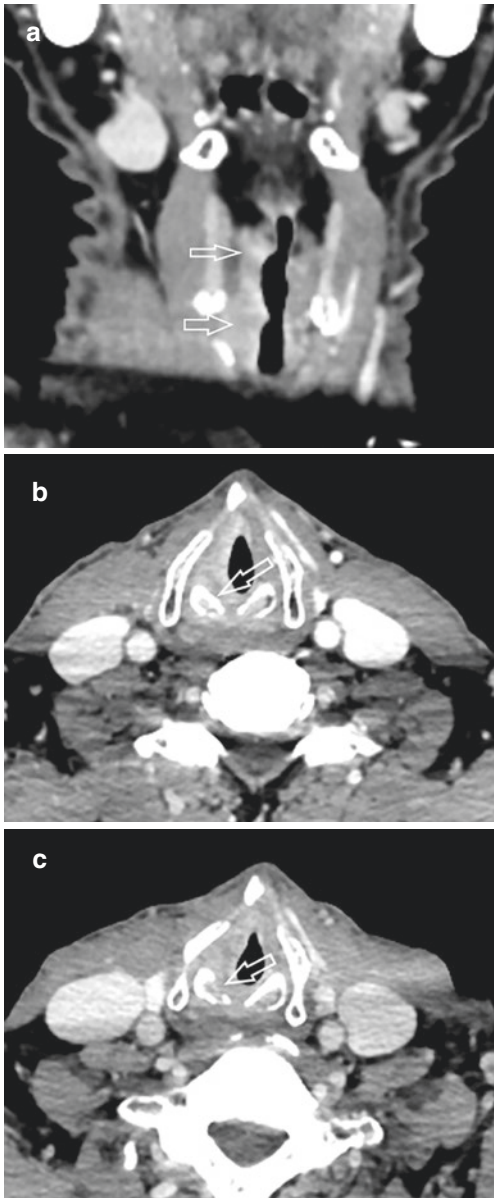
Laryngeal cancer. This patient presented with hoarseness for 3 months. (a) Coronal contrast-enhanced CT image shows infiltrative lesions at the right supraglottis, glottis, and subglottis (open arrows). (b) Axial contrast-enhanced CT image taken at the level of the subglottis shows an intact cricoid cartilage (open arrow). The CT findings cannot be distinguished from those of tuberculosis. The patient also had active pulmonary tuberculosis seen on CT (not shown). Biopsy of the laryngeal lesion showed squamous cell carcinoma. The patient was lost to follow-up for 2 months after biopsy. (c) Axial contrast-enhanced CT image taken 2 months later at the same level as (b) shows cricoid cartilage destruction typical of malignancy (open arrow)
